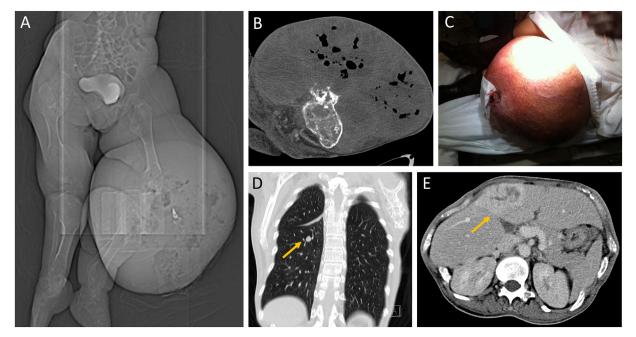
Woman diagnosed with Ollier disease without follow-up. On CT topogram (A) a voluminous mass in the left lower extremity is observed. CT image (B) shows a bone lesion with chondroid calcifications and destruction of the bone cortex due to degeneration of the disease to chondrosarcoma. The lesion is associated with a soft tissue mass with areas of heterogeneous attenuation and gas, compatible with abscess. Intraoperative photograph of the mass (C). Pulmonary (D) and hepatic (E) metastasis were reported on CT (arrows). (Color version of figure is available online.)
